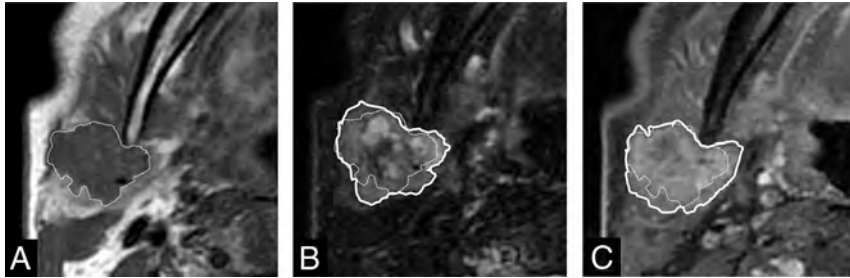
Corona sign on FS-T2WI and CE-FS-T1WI. Invasive CXPA (salivary duct carcinoma) of the right parotid gland in a 77-year-old man. MRI shows a homogeneous low-intensity tumor on axial T1WI (A), mixed high- and low-intensity signals on axial FS-T2WI (B), and irregularly enhanced signal on axial CE-FS-T1WI (C). The tumor size on FS-T2WI and CE-FS-T1WI (solid line) was larger than that on T1WI (dotted line). We defined these MRI findings as corona signs on FS-T2WI and CE-FS-T1WI.
